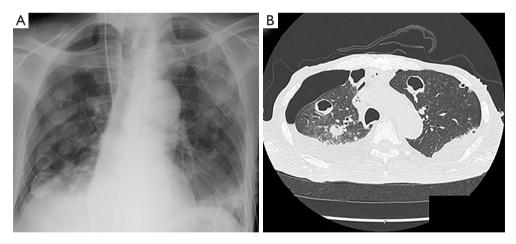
Images of right pneumothorax. (A) Chest radiograph revealed right pneumothorax and bilateral cavitary lesions. (B) Computed tomography showed right pneumothorax and bilateral septic emboli.
